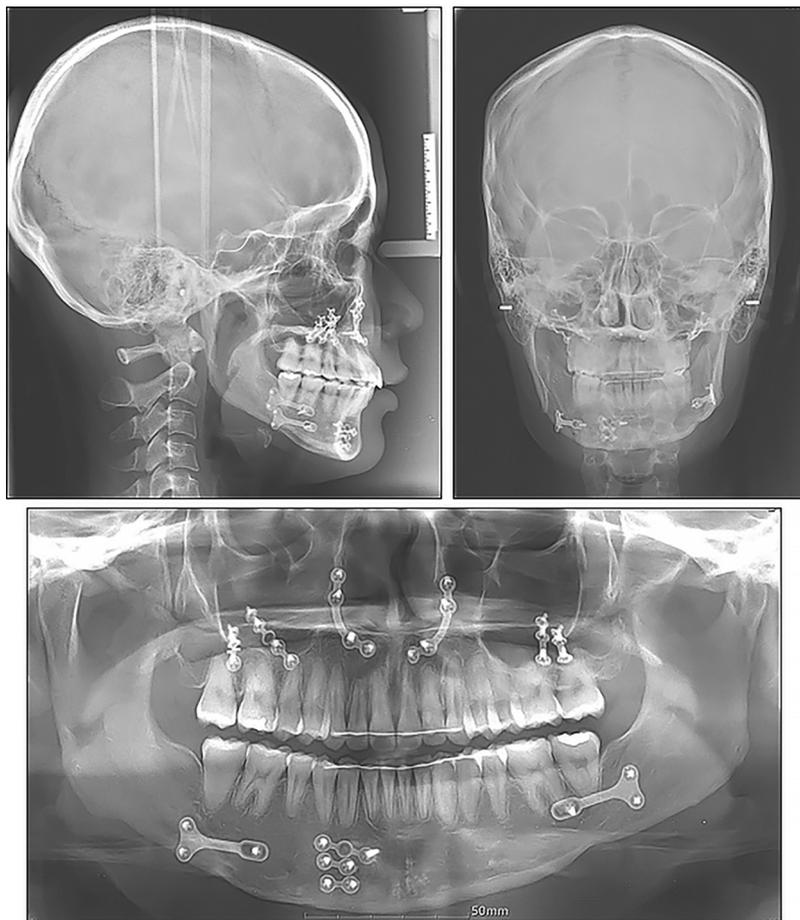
Posttreatment radiographs. Lateral and posteroanterior cephalograms and panoramic radiographs are shown.
